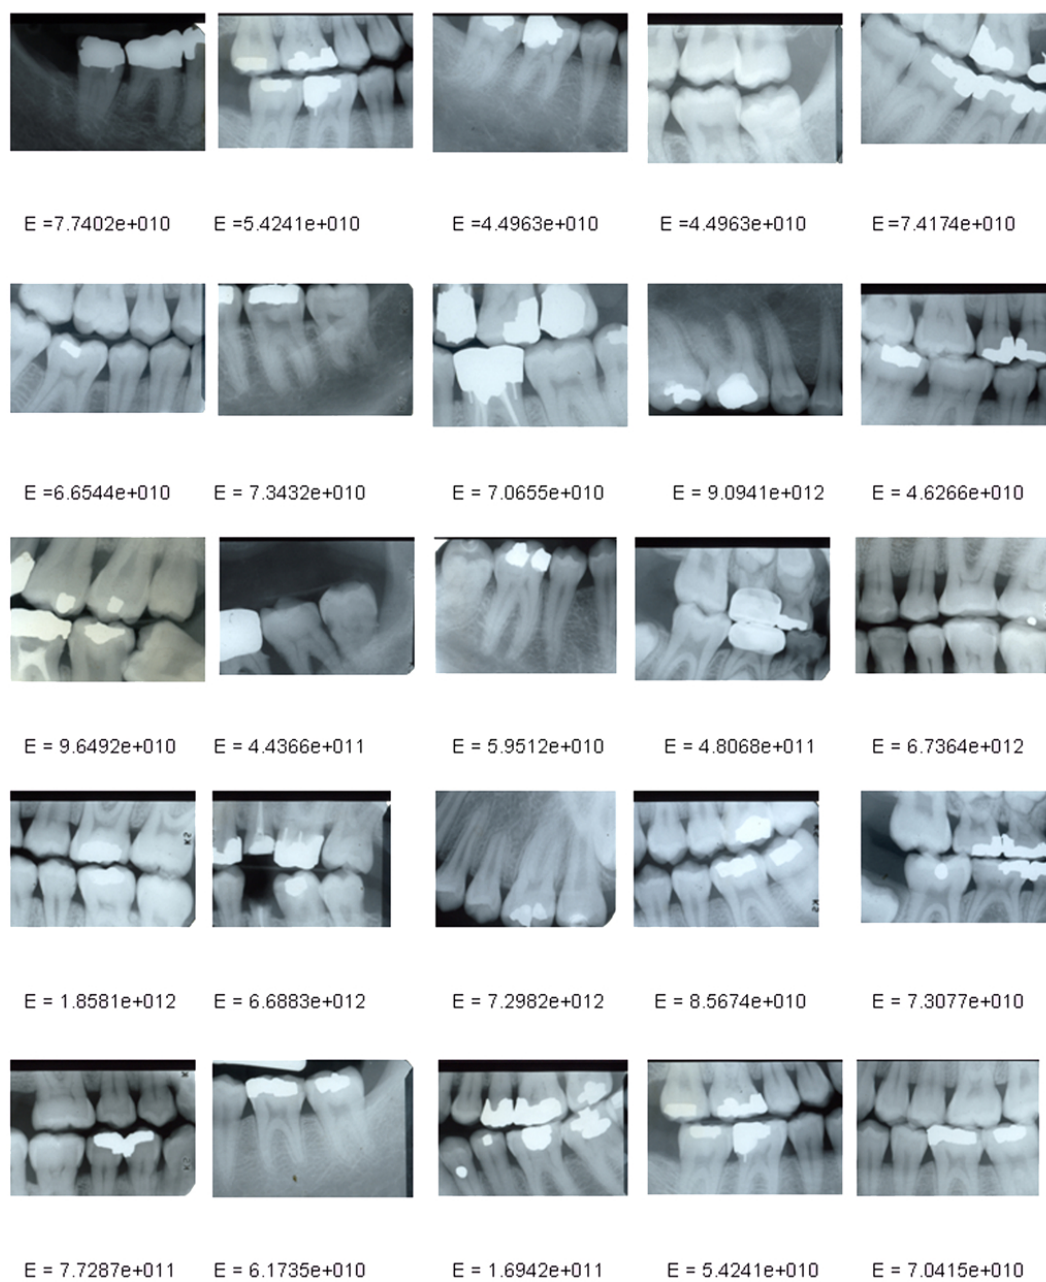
Results of a small identification trial on a database consisting of 25 x-rays
